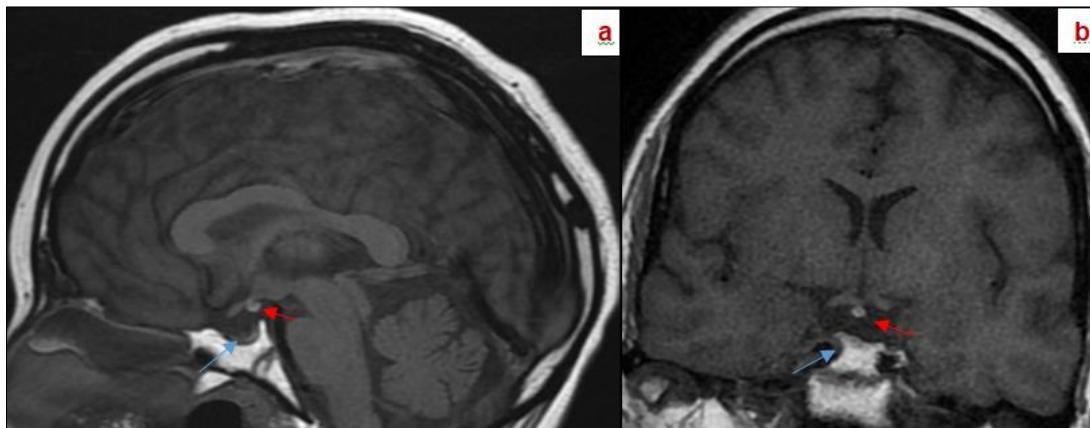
Sagittal (a) and coronal (b) T1-weighted MRI sequences showing a hypoplastic anterior pituitary (blue arrow) and an ectopic posterior pituitary (red arrow).
